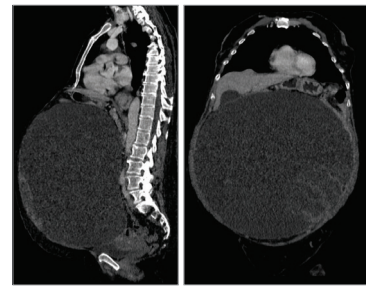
Sagittal (left) and coronal (right) contrast-enhanced abdominal computed tomography images showing a large abdominal mass.
